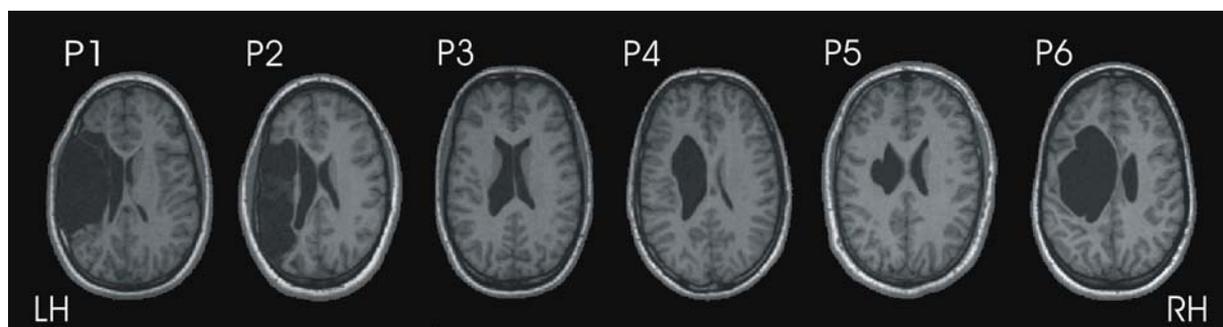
T1-weighted datasets of patients with lesion-induced right-hemispheric language production
